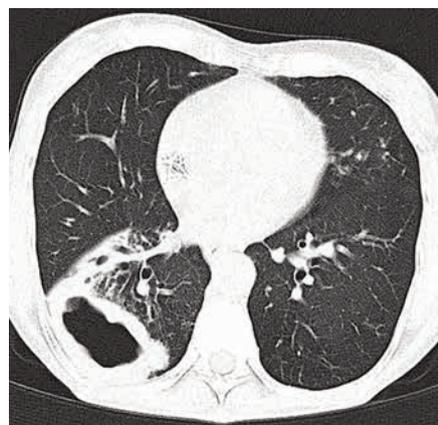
CT scan image demonstrating right lower lobe cavitory disease associated with NTM infection. Despite the cavity size, the thick walled nature of the cavity and the focal juxtaposition to the parietal pleura render it amenable to VATS resection.
